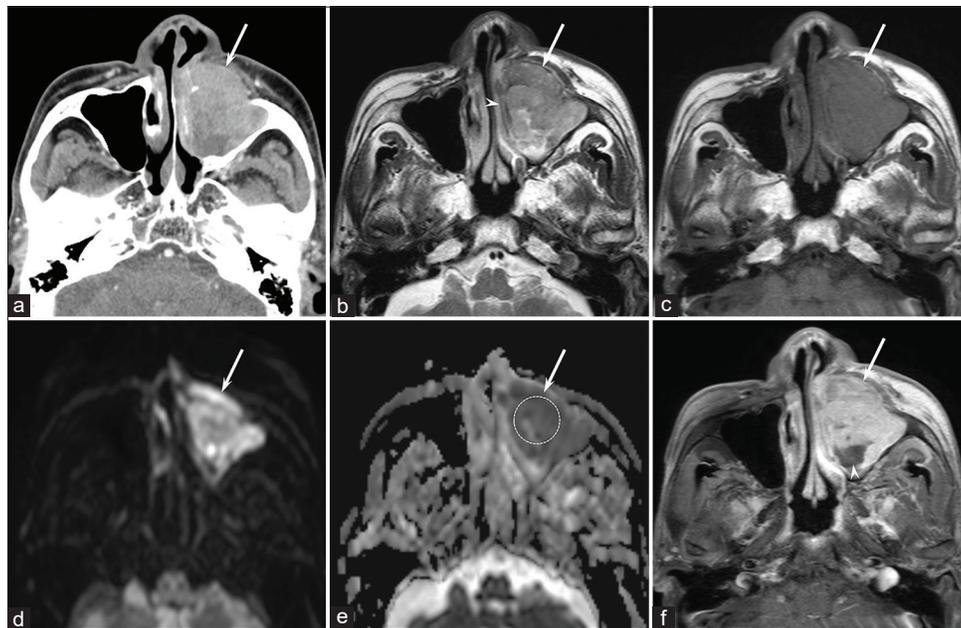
An 81-year-old man with HPV-negative SCC of the maxillary sinus. (a) Enhanced CT image shows a heterogeneously enhanced bulky mass (arrow) with destructive growth. (b) T2-weighted image (TR/TE, 3646/90 ms) shows a heterogeneously hypo- to hyperintense mass (arrow) with invasion of nasal cavity (arrowhead). (c) T1-weighted image (TR/TE, 662/15 ms) shows a hypointense mass (arrow). (d) Diffusion-weighted image (TR/TE/TI, 5490/72/170 ms) shows a heterogeneously hyperintense mass (arrow). (e) ADC map shows relatively low ADCmin ($0.724 \times 10^{-3} \text{ mm}^2/\text{s}$) and ADCmean ($1.089 \times 10^{-3} \text{ mm}^2/\text{s}$) (arrowhead). The dotted line shows the contours of region of interest placed on solid components. (f) Gadolinium-enhanced fat-suppressed T1-weighted image (TR/TE, 662/15 ms) shows a heterogeneously enhanced bulky mass with necrotic area (arrowhead) and invasion of subcutaneous tissue (arrow).
